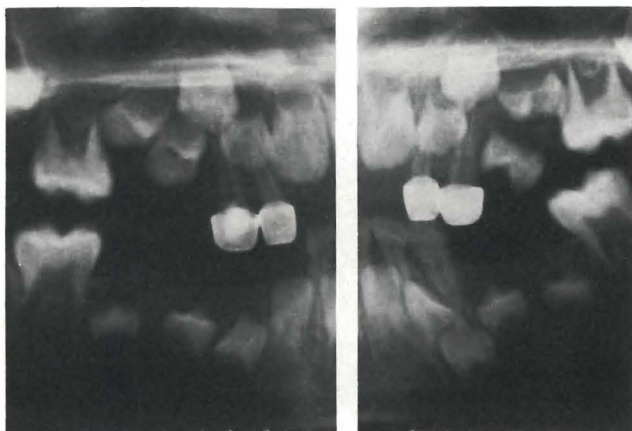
Panoramic radiograph of maxillary left first premolar with no root development, in a stage of premature eruption.
